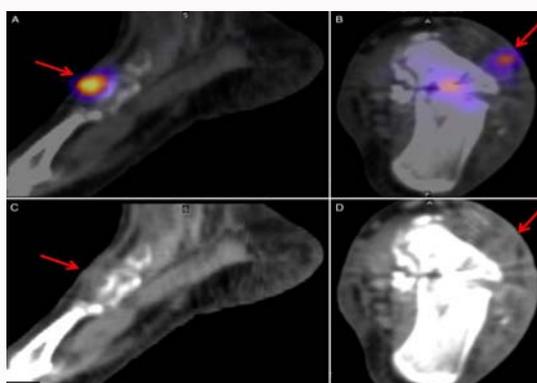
Fusion SPECT/CT images (A,B): of the left foot show a focus of increased ^{111}In -WBC uptake within the soft tissues adjacent to the medial cuneiform and talus, which corresponds with soft tissue swelling on the low-dose CT images (C,D): and indicate infection within the soft tissues (arrows).
